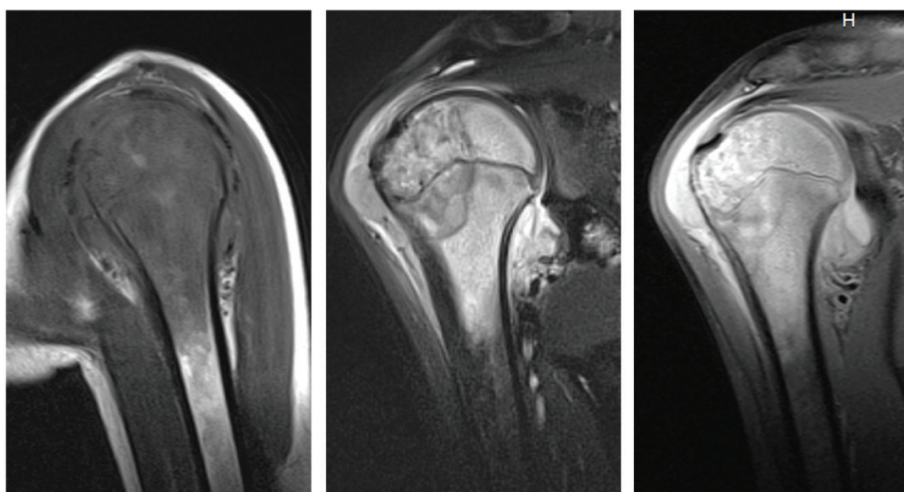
Sagittal T1, Coronal T2, and PD, MRI of the right shoulder with an epiphyseal tumor and surrounding soft tissue and metaphyseal edema.
